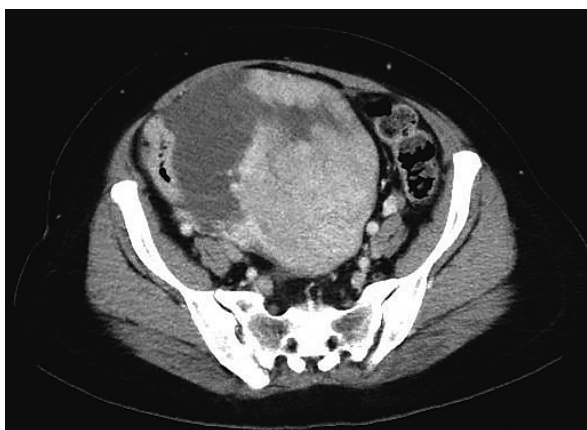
CT (contrast CT)
